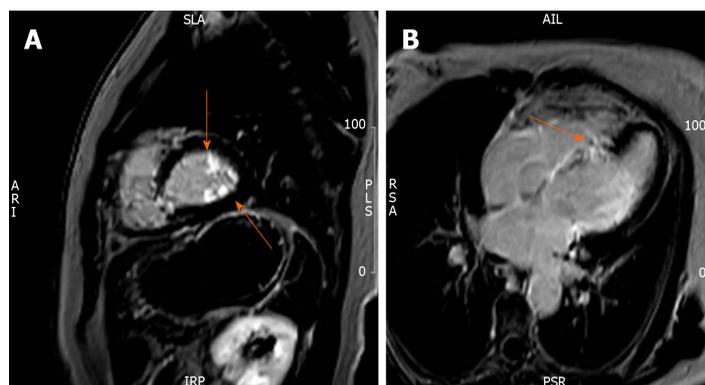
T1-weighted cardiac magnetic resonance image with delayed enhancement. A: Hyperenhancement of the papillary muscles (arrows); B: Patchy transmural fibrosis of the septum (arrow).
